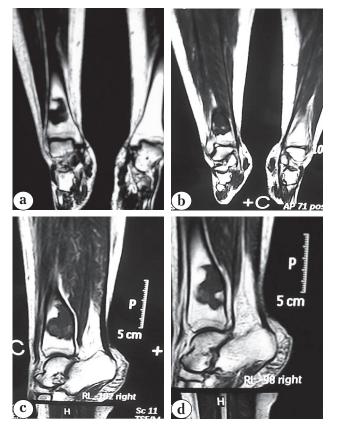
Preoperative magnetic resonance imaging, T_1 coronal (*a*), T_2 coronal (*b*), T_1 sagittal (*c*), and T_2 sagittal (*d*) showing the location, extent and nature of the lesion with low signal intensity in T_1 weighted and high signal intensity in T_2 weighted
